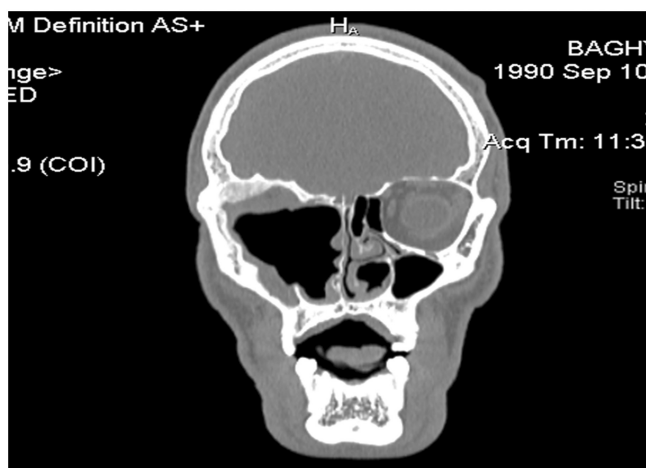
Coronal CT scan of the patient after 1 year follow-up.
